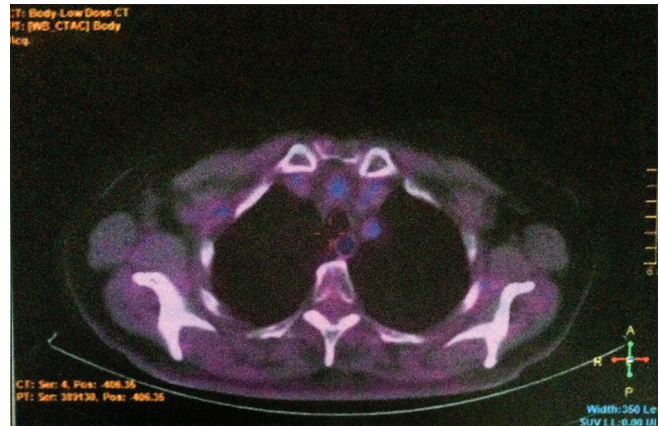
Positron emission tomography/computed tomography after combined treatment on January 2014
